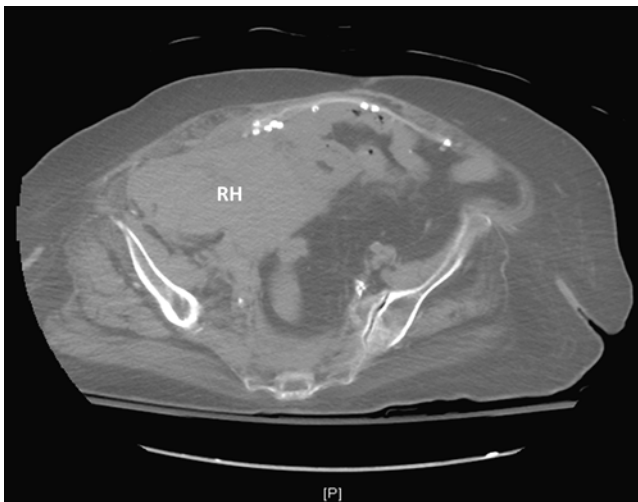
CT scan without contrast showing a retroperitoneal hematoma (RH)
